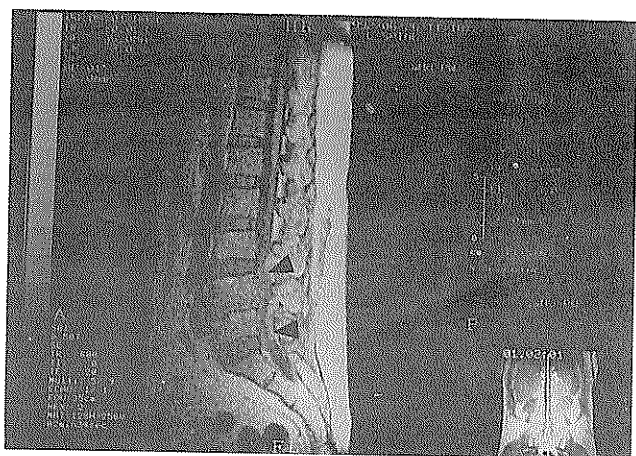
Magnetic resonance imaging study. Midsagittal scan of the lumbosacral spine taken with a spin-echo technique, T1-weighted image. A soft tissue mass extending from L3-4 to S1 vertebrae (arrows) and blocking the continuity of subarachnoid space.
